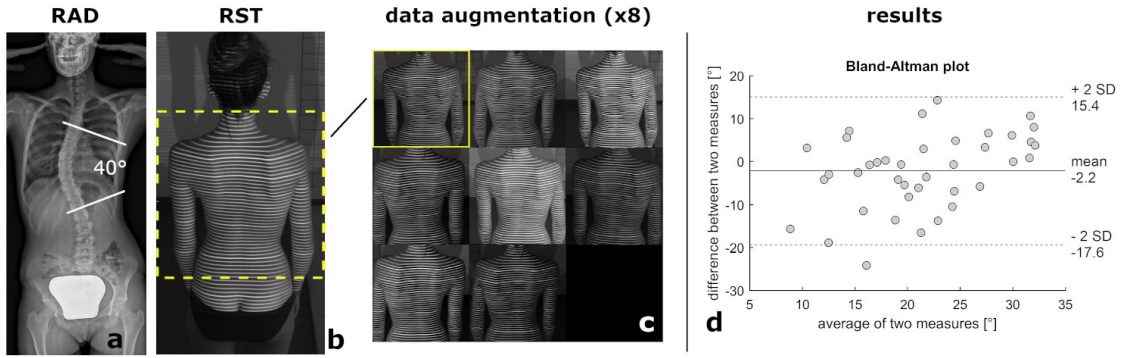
Radiographic (a) and rasterstereographic (b) image of one subject, and example of data augmentation (c) from cropped and resized section. Right panel (d): Bland-Altman plot for true and predicted Cobb angle.
